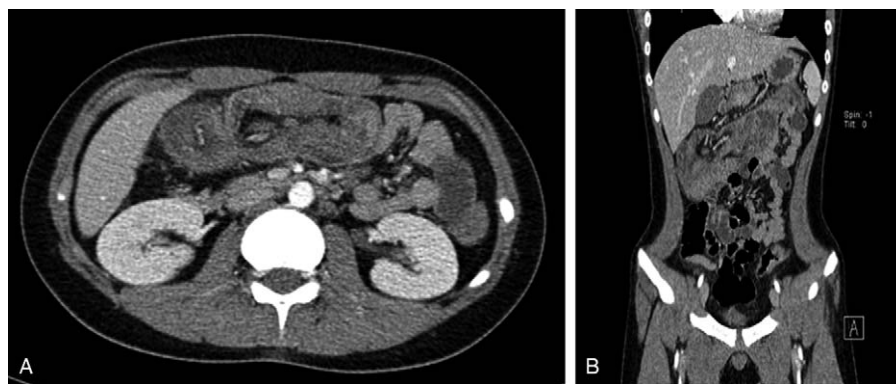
Abdomen and pelvic CT. (A) It shows inversion of distal ileum, mesenteric fat, and multiple mesenteric lymph node enlargement. (B) Coronal image shows same findings. CT=computed tomography.
